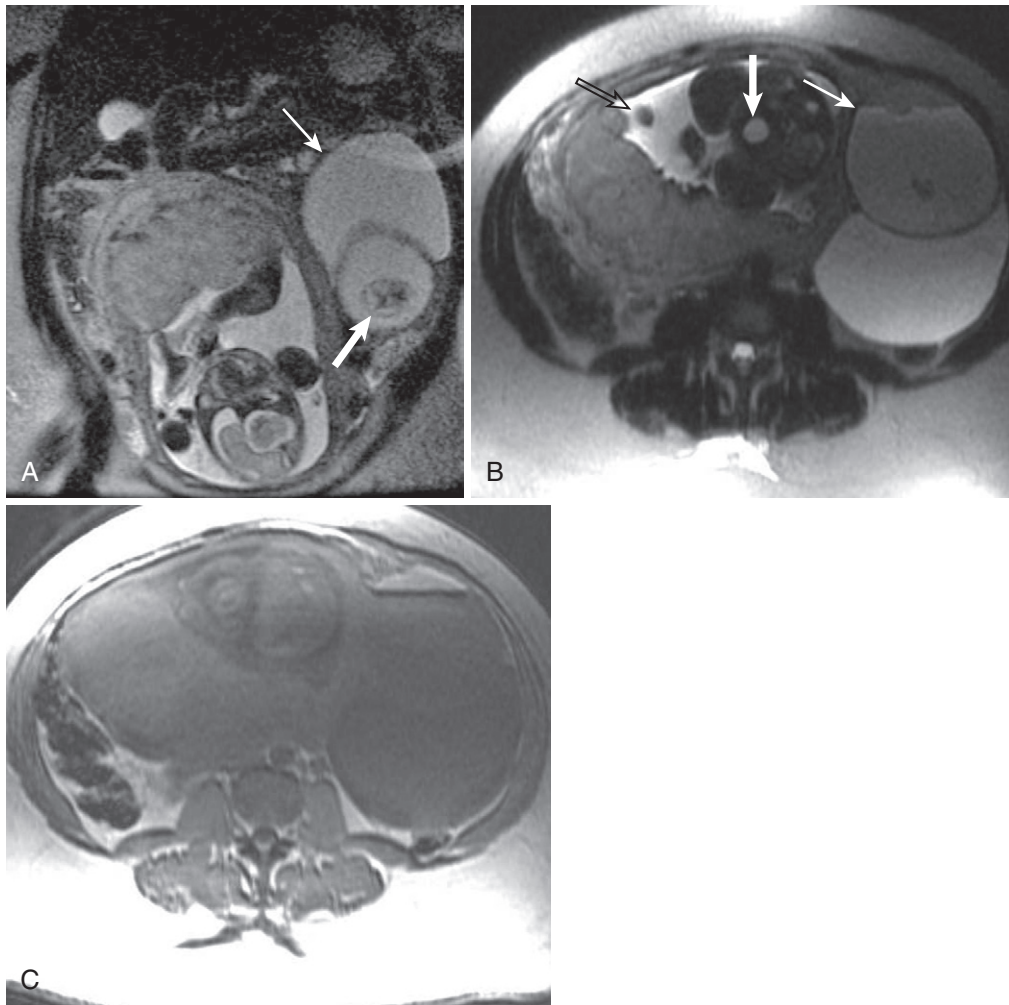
Dermoid cyst, fluid-fluid level. A, T2-weighted coronal localizing image in a pregnant patient (note the vertex presentation and fundal placentation) also show a large left adnexal, at least biloculated cystic lesion (*thin arrow*) with internal debris and/or nodularity (*thick arrow*). B, The axial T2-weighted image through the level of the fetal bladder (*thick arrow*) shows a fluid-fluid level (*thin arrow*) with dependent fluid isointense to amniotic fluid (*open arrow*). C, The fluid-fluid level signal intensities are reversed on the out-of-phase T1-weighted image with the nondependent fluid isointense to subcutaneous fat. The signal void at the fluid-fluid level suggests destructive interference between the water (dependent) and the lipid (nondependent) protons—phase cancellation artifact—additional evidence of fat composition and the diagnosis of a dermoid cyst.
